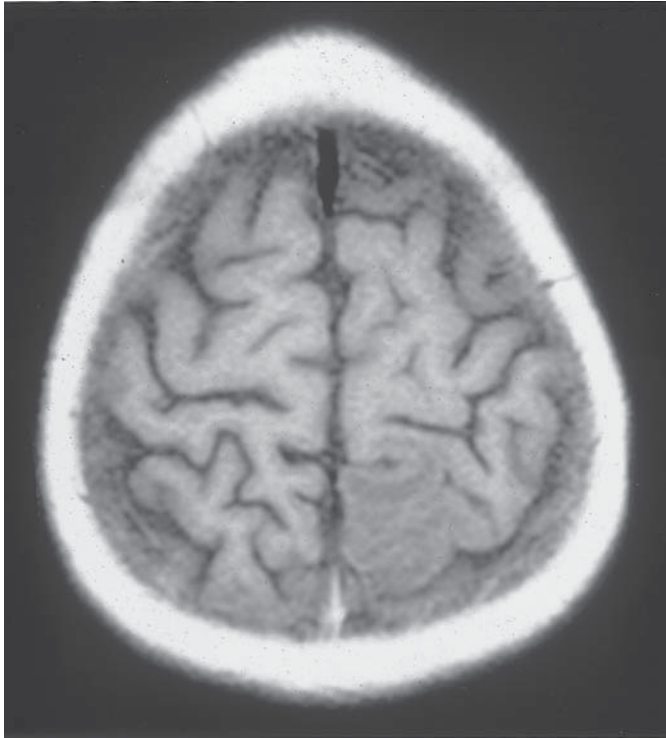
Signal changes in the left occipital lobe of a patient with cyclosporine/hypertensive encephalopathy. Although often bilateral it is not uncommon for the MRI changes to be asymmetric.
